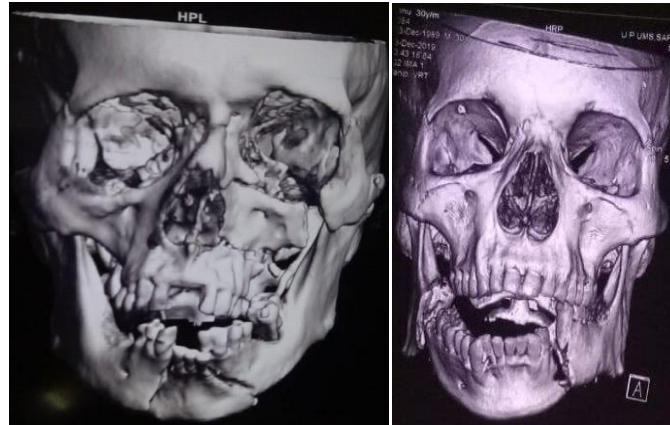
3D CT scan showing LEFORT CLASS, I, II, III, with mandible or without mandible
